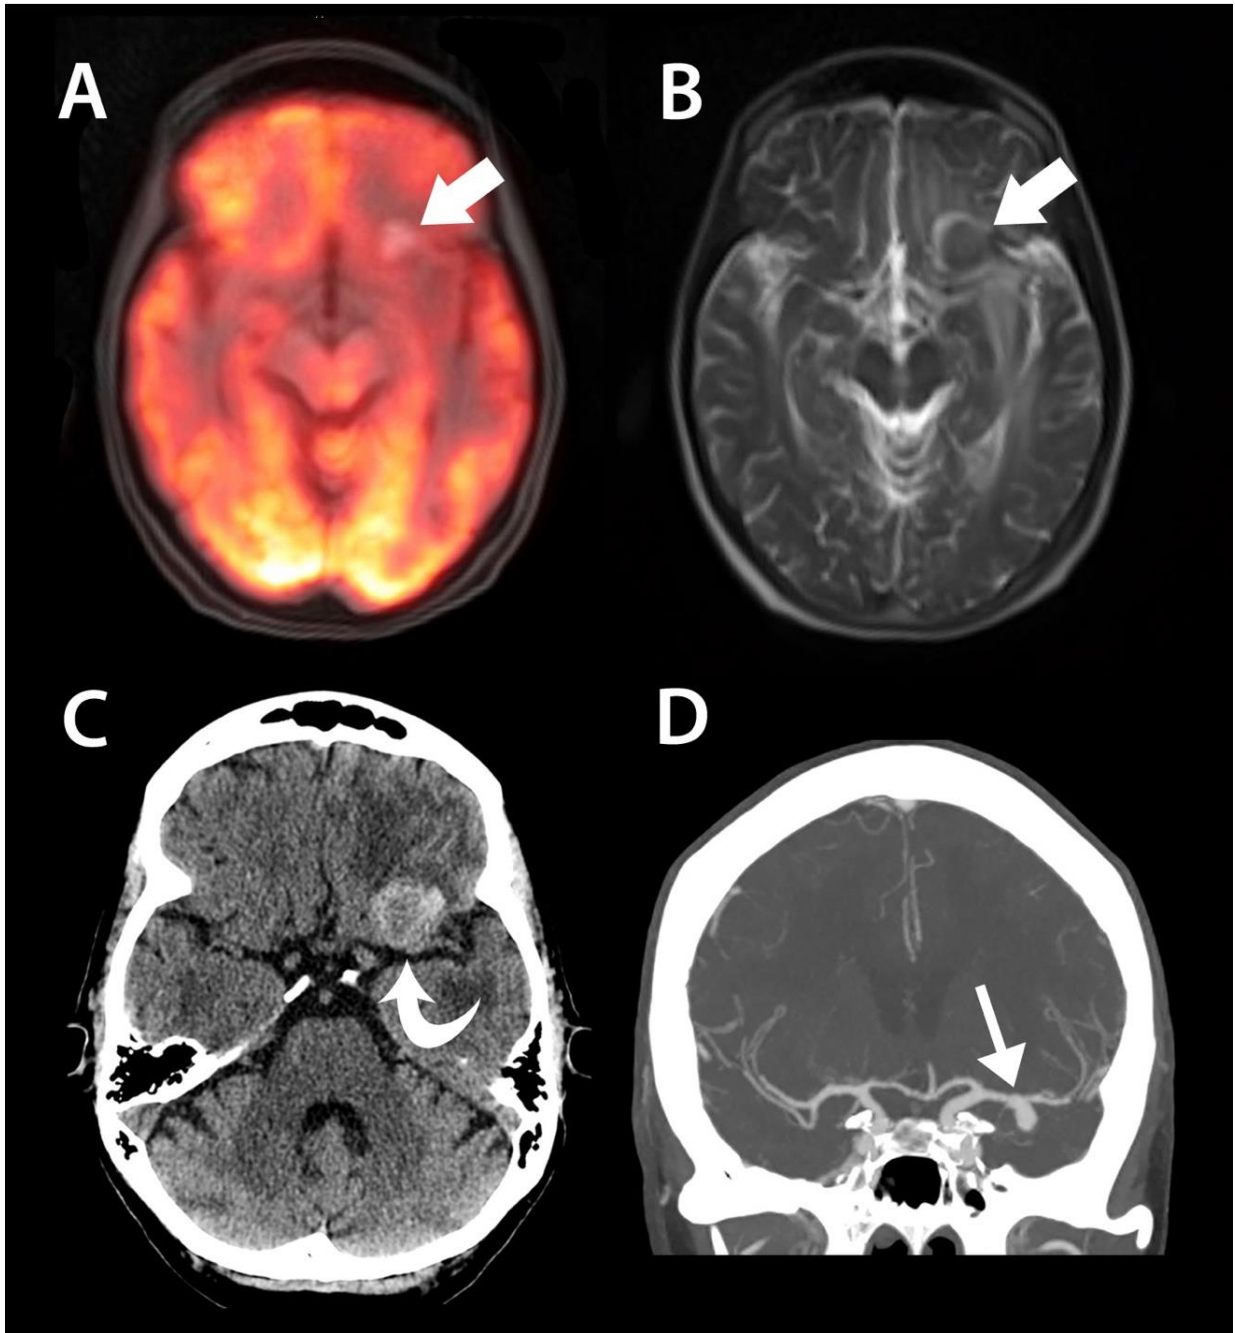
64-year-old female with breast cancer and no neurological symptoms. A. PET/MR T1 fat saturated axial fusion. B. Axial T2 HASTE. C. Axial non-contrast CT head. D. CT angiogram (CTA) coronal maximum intensity projection image (MIP). There is T1 hyperintense and T2 hypointense signal within thrombosed part of the of the left middle cerebral artery aneurysm which is hyperdense on non-contrast CT head. CTA coronal MIP shows patent part of the inferiorly oriented saccular aneurysm.
